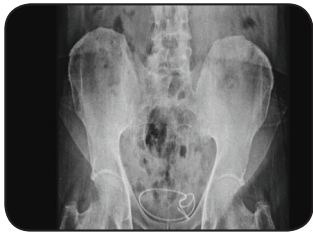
X-ray KUB showing coiled stent in the bladder.
